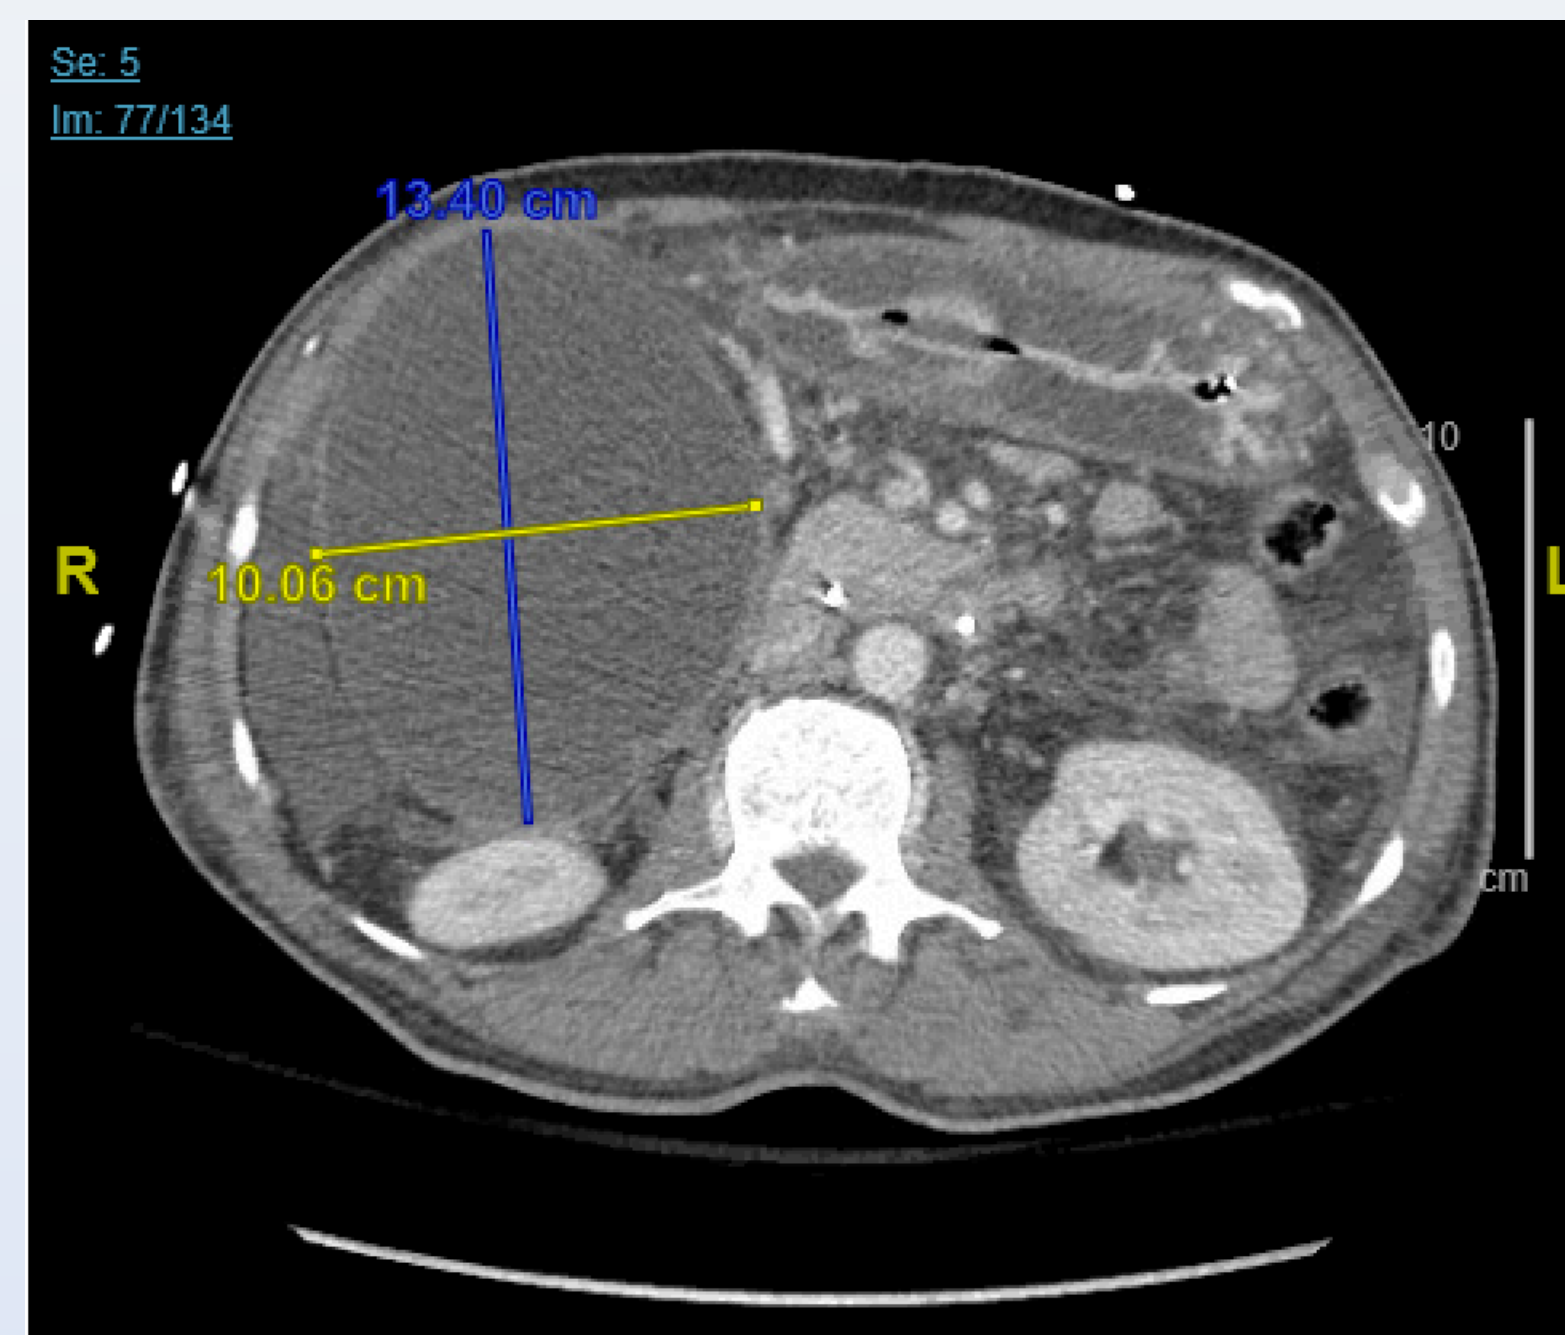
CT Abdomen (axial): Distended gallbladder mucocele measuring 13 x 10 cm compressing duodenum, small amount of ascites
